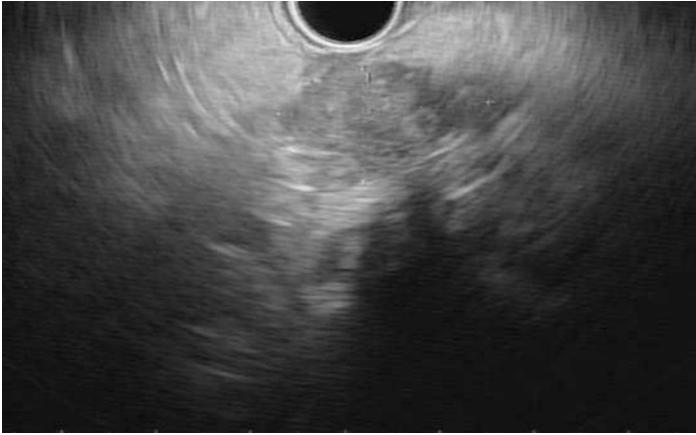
Endoscopic ultrasound image of a pancreatic adenocarcinoma: hypoechoic, heterogenous oval-shaped lesion with irregular borders
